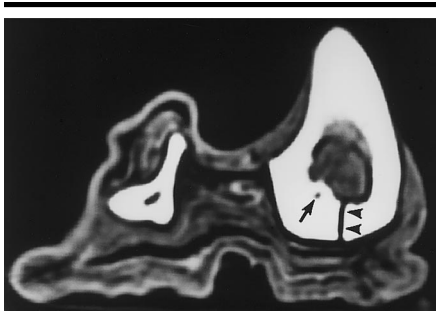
Transverse CT section through the diaphysis of the right tibia and fibula (obtained on May 3, 1994) shows thick cortices, a well-developed nutrient canal (arrow), and an elongated anteroposterior diameter of the bones, also present on the left side. It is surmised that this configurational oddity indicates a biomechanical adaptation to the requirements of life and labor on the slopes of the Alps. The cracked tibia (arrowheads) is attributed to trauma acquired during the recovery effort.
